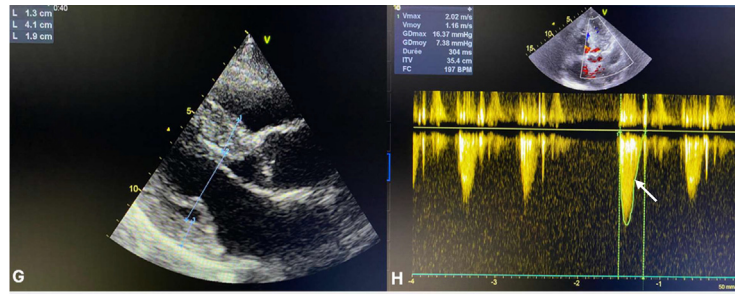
Transthoracic echocardiography of the female sibling with FRDA revealing a hypertrophic cardiomyopathy, and a maximal gradient at rest 16.37 mmHg (white arrow).
